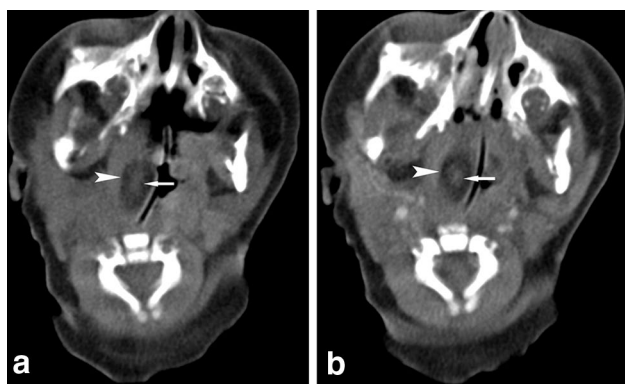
A right nasopharyngeal hairy polyp in a girl aged 1 day. a Plain CT scan shows the fat density mass in the right lateral nasopharyngeal wall (arrowhead) with soft tissue density core (arrow). b Contrast-enhanced CT scan shows mild enhancement of the core, and non-enhancement of the rest of the mass
